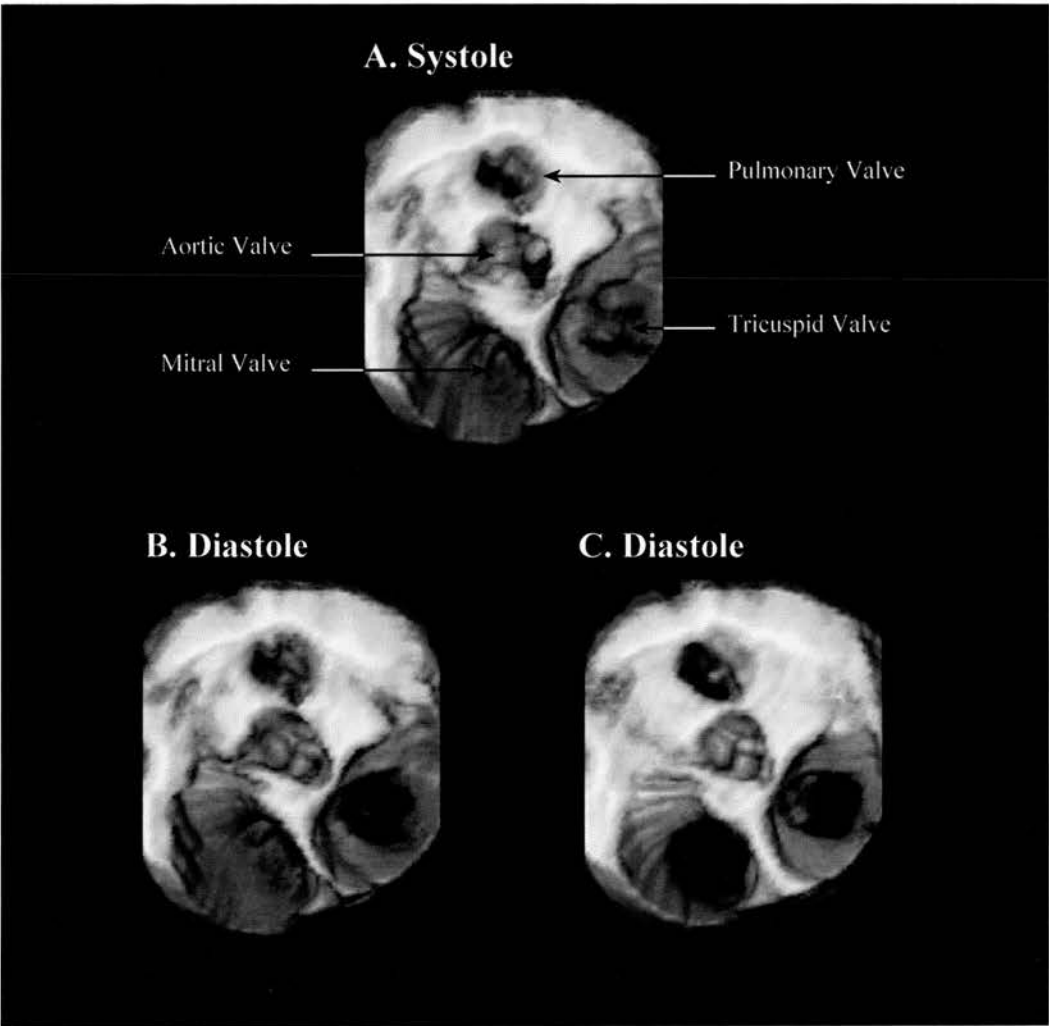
Examples of volume-rendered transoesophageal three-dimensional reconstruction of the heart: short-axis view at the level of atrio-ventricular valves directed from above (an atrial perspective). During systole (A) and diastole (B, C) two vegetations are seen in the ascending aorta, just in front of the aortic valve corresponding to acute bacterial endocarditis of the aortic valve. Elevated right heart pressure with mild tricuspid and pulmonary valves regurgitation.
